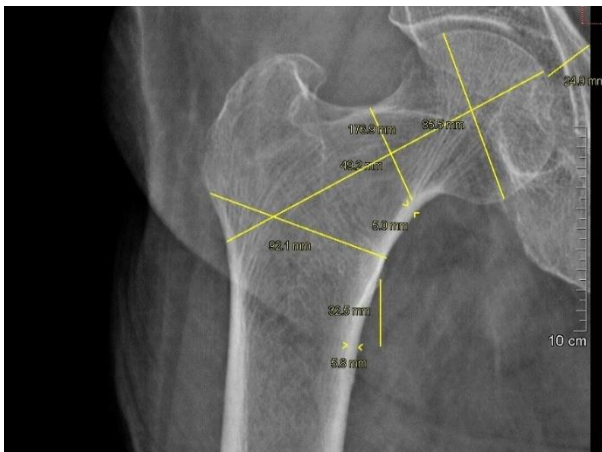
Hip geometrical measurements on a digital radiograph of Normal Pre Menopausal Indian woman aged: 28, the measured Total hip BMD by the DXA in the same individual was: 0.966g/ Cm 2
